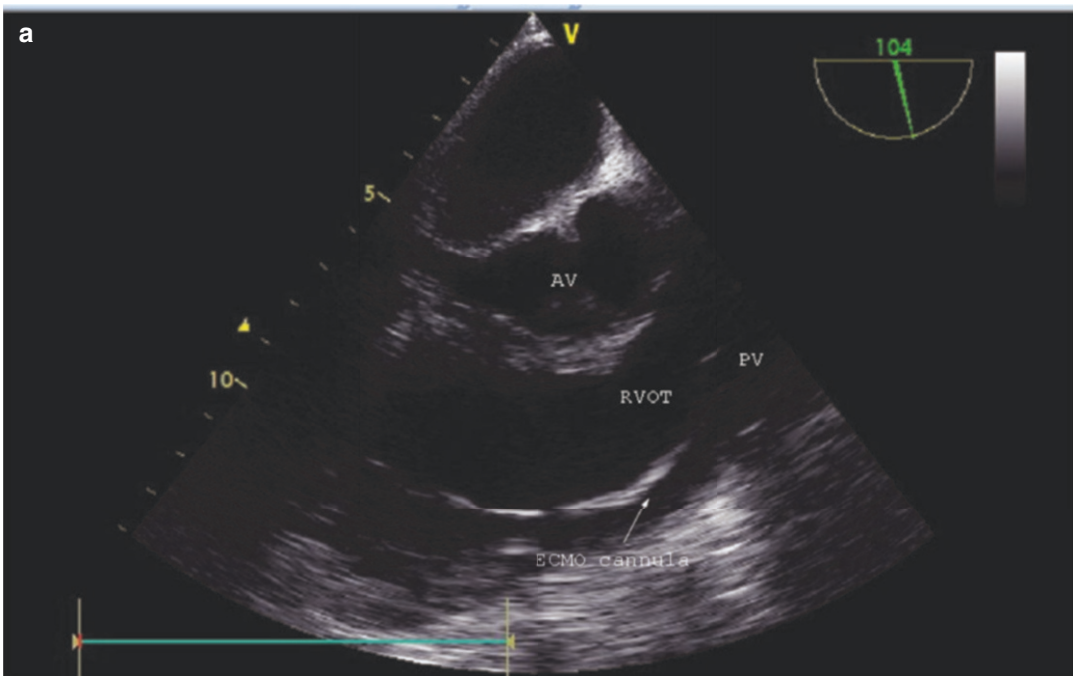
Transesophageal Echocardiogram (TEE) ME RV inflow-outflow view focused on the outflow showing. (a) ECMO Cannula in the RVOT. (b) ECMO Cannula advanced into the MPA (Main Pulmonary Artery)
